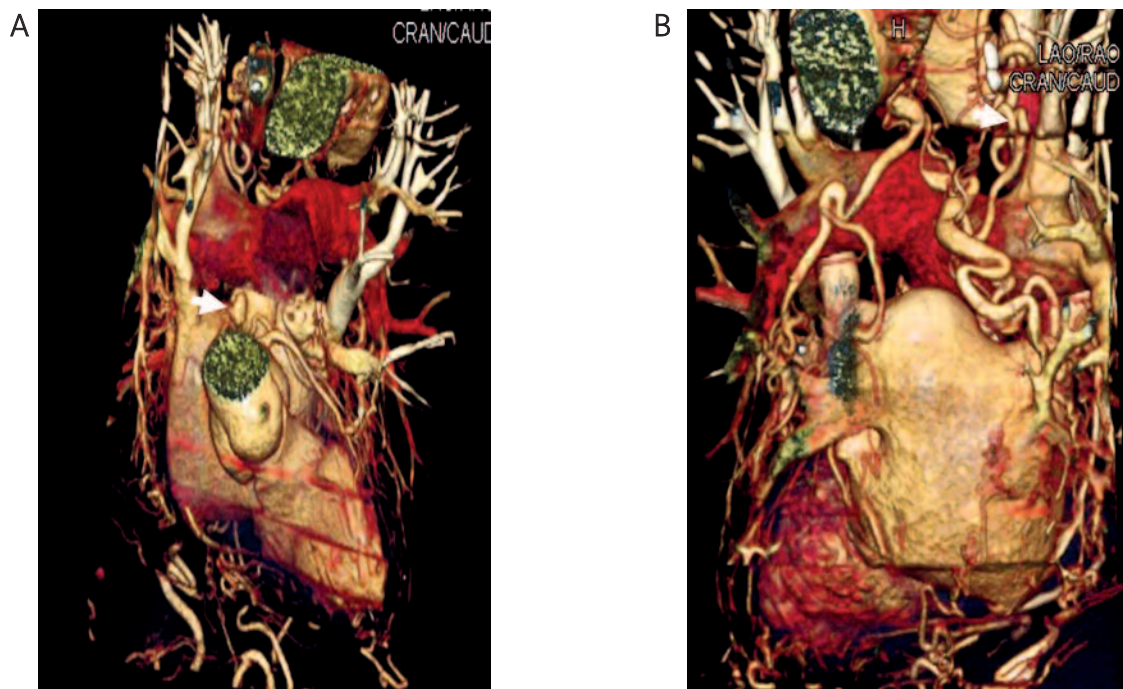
Three-dimensional volume rendered image from multidetector computed tomography coronary angiography, showing the saccular fistulous communication (arrow) between the circumflex artery and bronchial artery (A) and fistula originating from the sinoatrial branch of the circumflex artery and coursing to right atrium (B)
